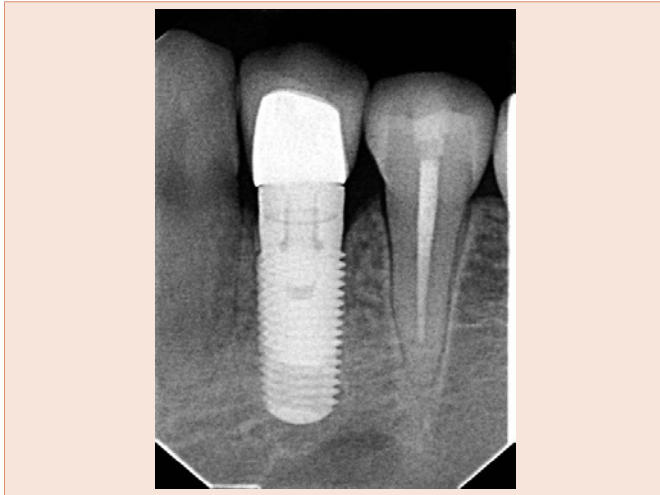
Radiograph of the implant after the cementation of the temporary crown.
